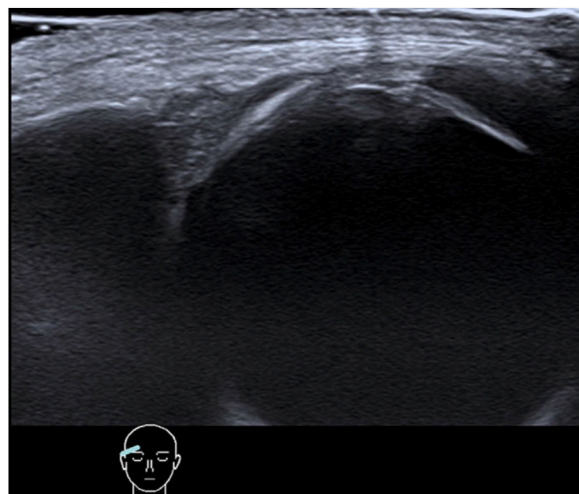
Subjective visual symptom score value Level 0, LGUS lacrimal gland ultrasonography Level 0.
